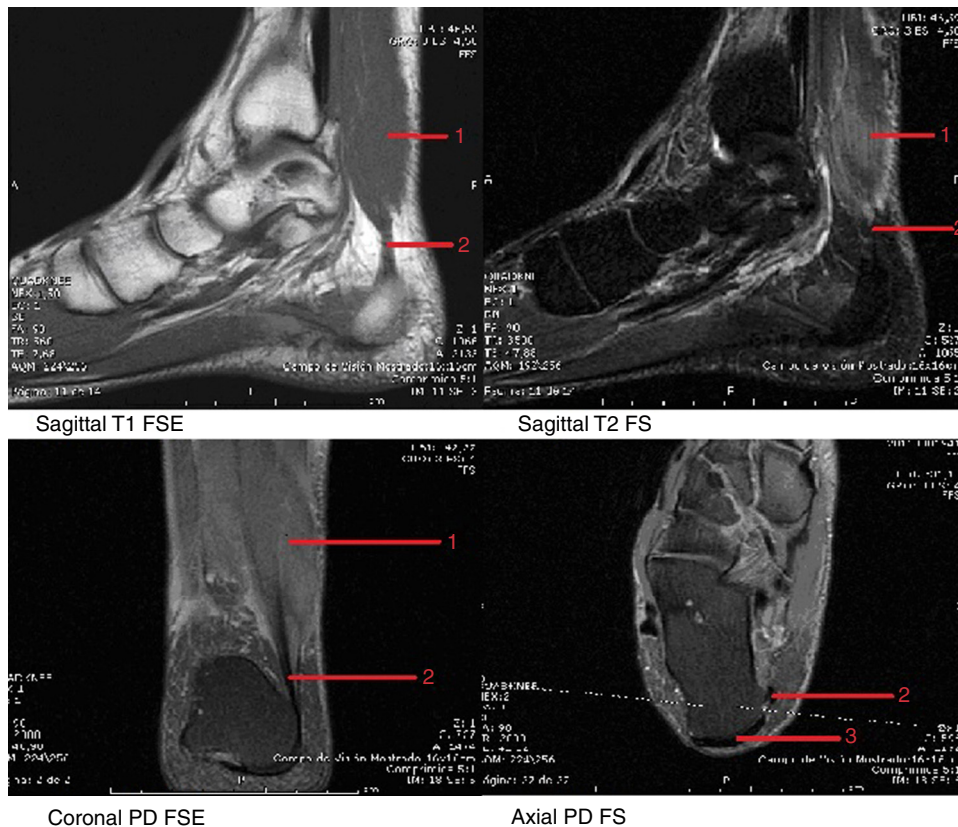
MRI mosaic. 1. Accessory soleus muscle; 2. Accessory soleus tendon; 3. Achilles tendon.
